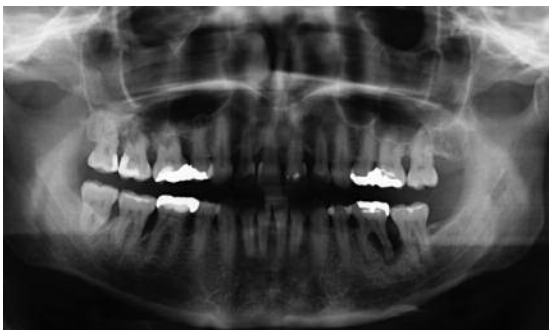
X-ray of the initial situation.
